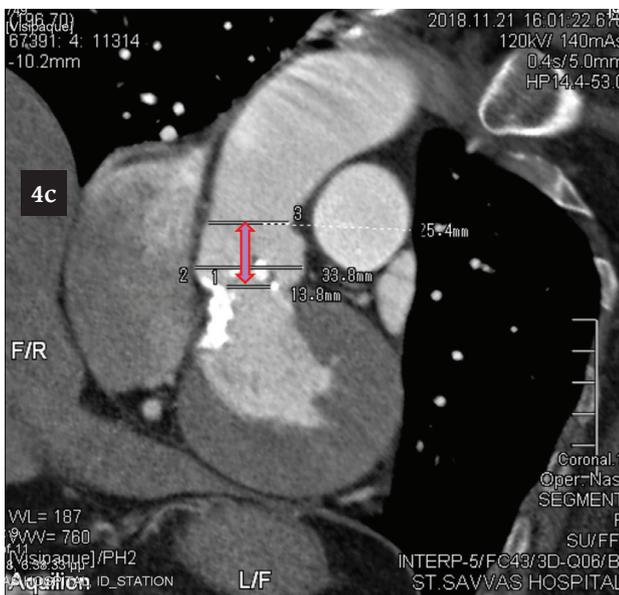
a- b) Measurements of the Sinus Valsalva on the derived axial CT images. c) Double-headed arrow shows the maximal height of the sinus Valsalva.
